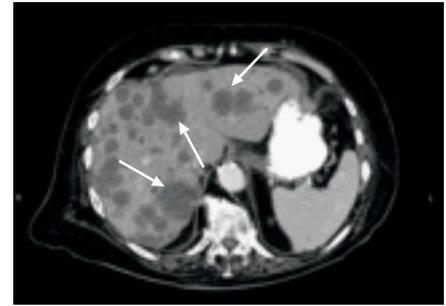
CT image of a multifocal hepatocellular carcinoma (arrows).
